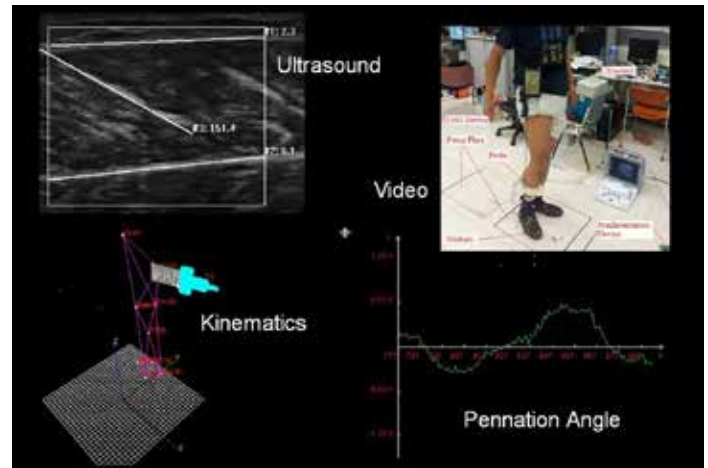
Compound motion analysis using conventional optical kinematic tracking method and sonomyography, which represents architectural change of muscle extracted from real-time ultrasound images during muscle contraction.
